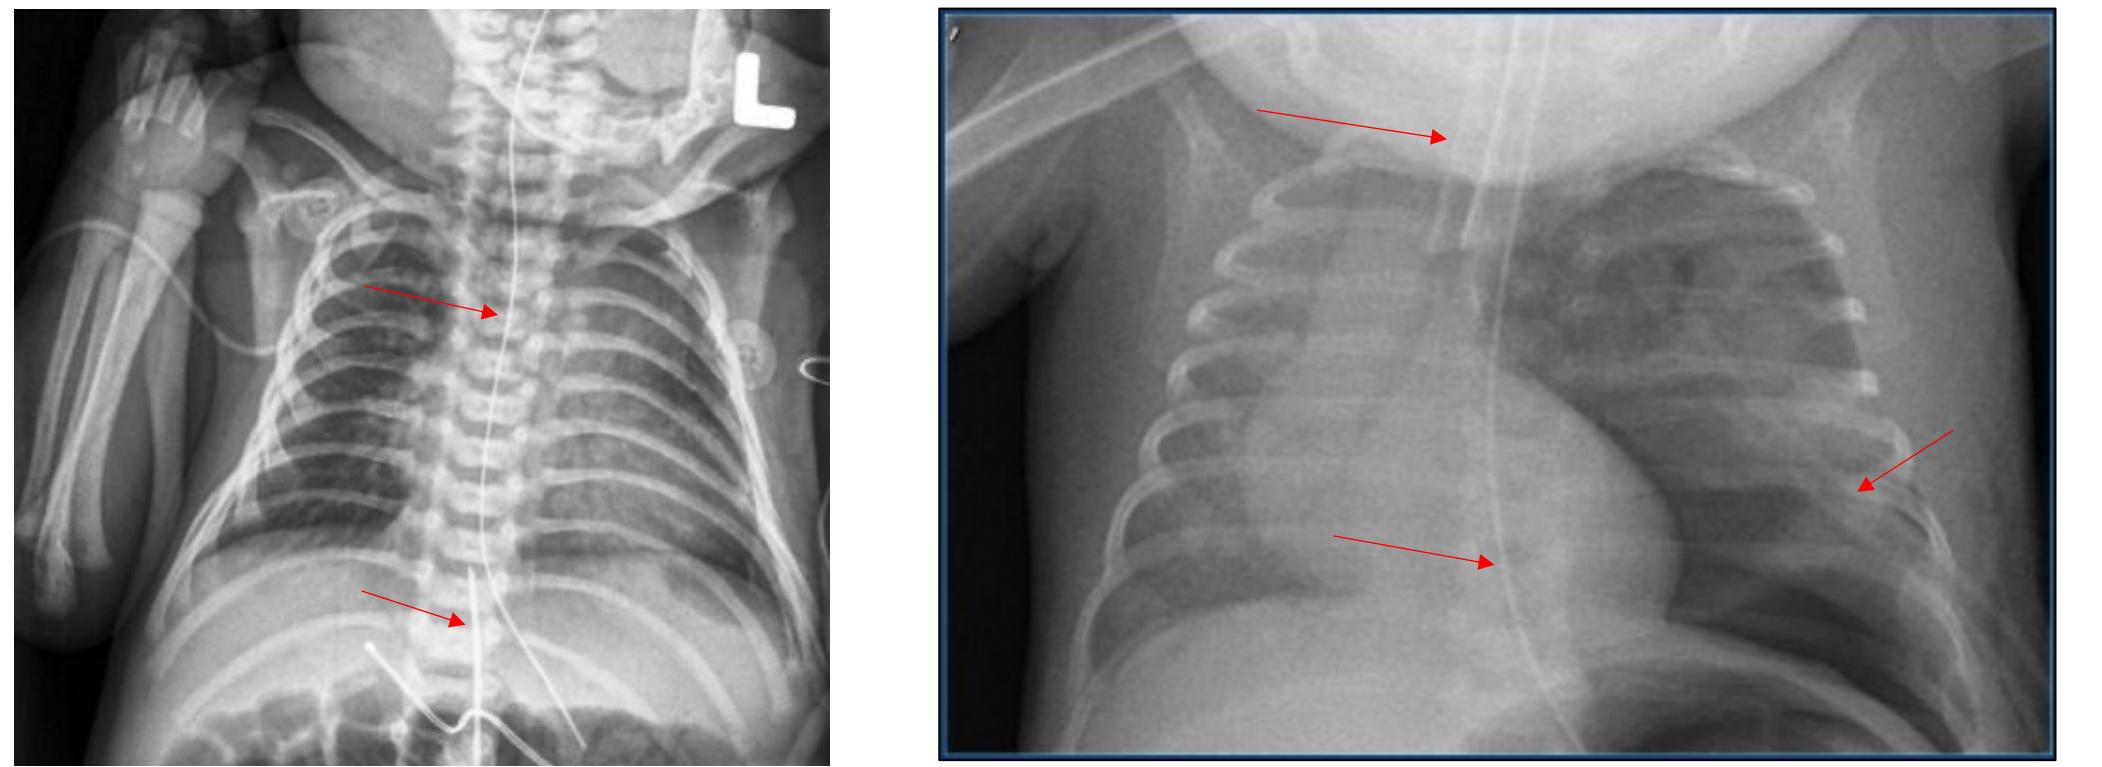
Two typical pediatric radiographs with lines marked by red arrows.
